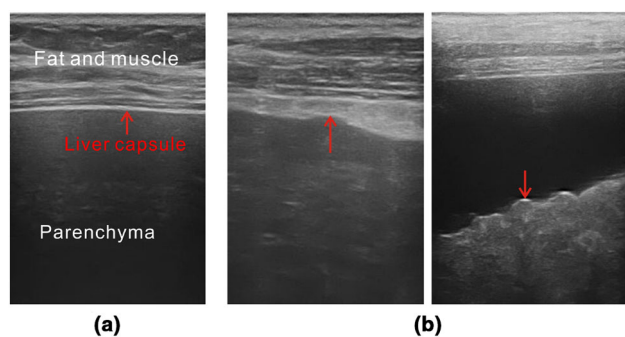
Normal/cirrhosis liver capsules in ultrasound images
